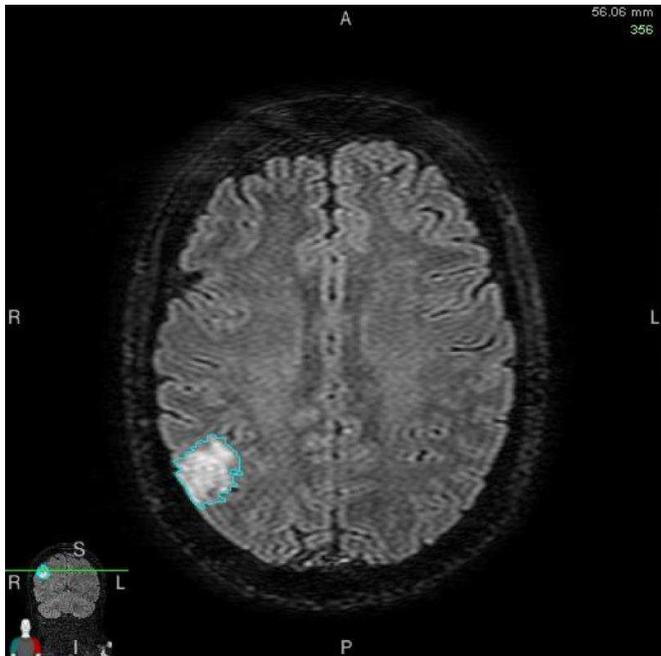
Axial FLAIR image with Gadolinium showing contour around the tumour margin used to calculate tumour volume. The overall tumour volume is the product of the contoured areas on each axial slice, the slice thickness and inter-slice gap.
